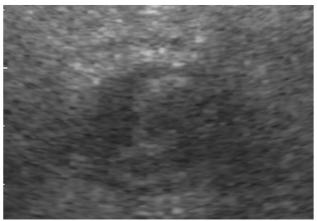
Intestinal wall hypertrophy by colon wall phlegmons (sonography guided puncture and antibiotic conservative cure); LAS transverse
